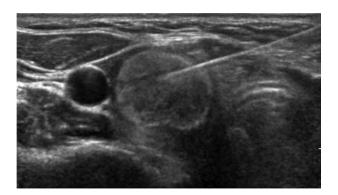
Fine-needle aspiration biopsy ultrasound of a right thyroid nodule performed April 20, 2021.
